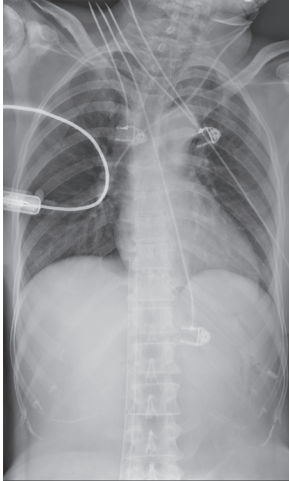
X-ray—the drainage venous cannula in intra hepatic portion of IVC
